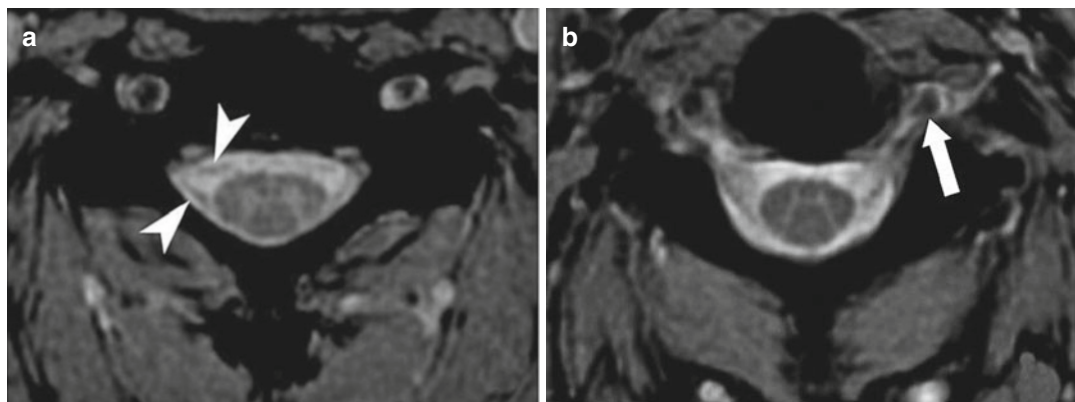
Spinal cord axial MRI GE T2-weighted sequences. This is a good representation of the medullary anatomical structures: note the butterfly shape (a) or “H”
